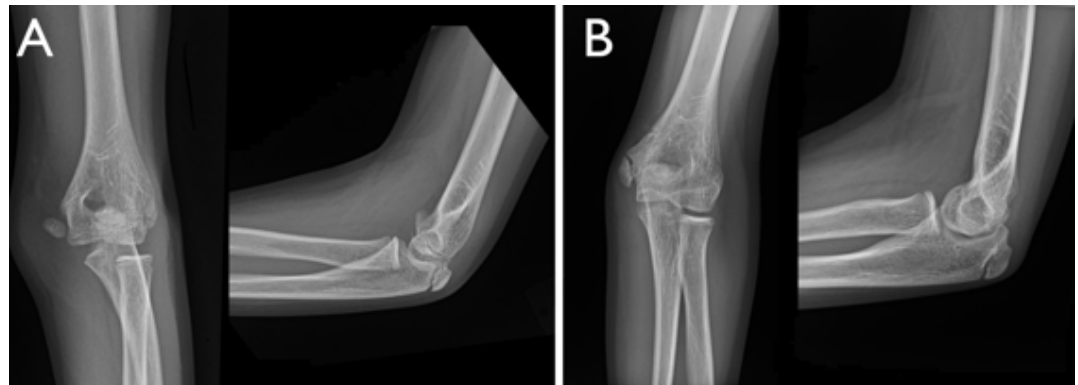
Initial radiographs, anteroposterior and lateral, showing a medial epicondyle fracture (A). Radiographs at 2 months show maintenance of medial epicondyle reduction (B).
